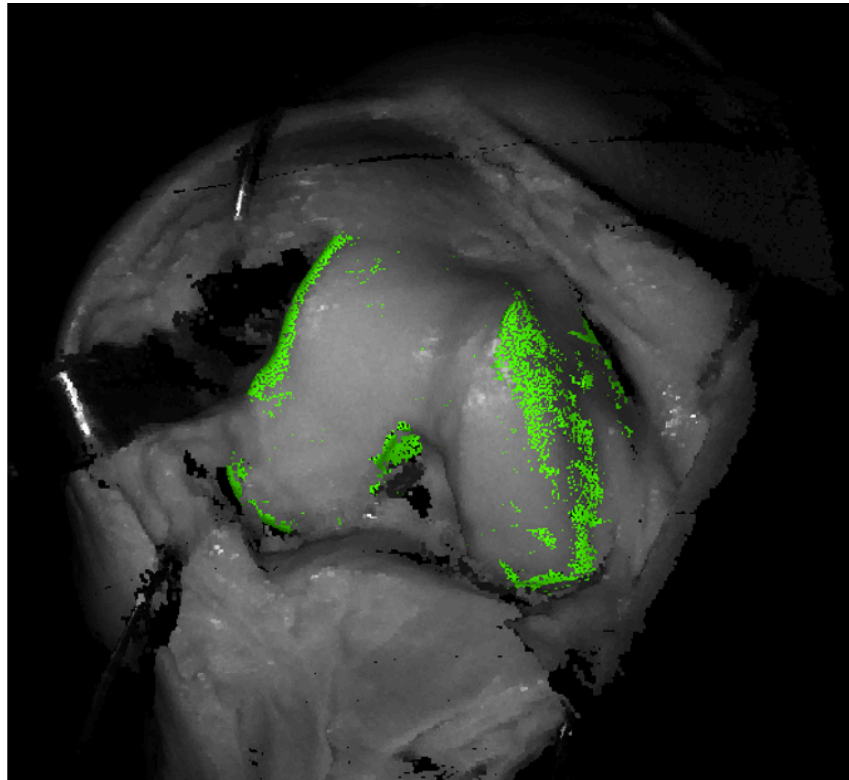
Pre-operative CT (green) registered into the scanner's coordinate system using VISIE scan (greyscale) with proprietary algorithm. The cartilage of the optical scan prevents visibility to the CT model, due to correct registration placing the bony surface below the cartilage.
